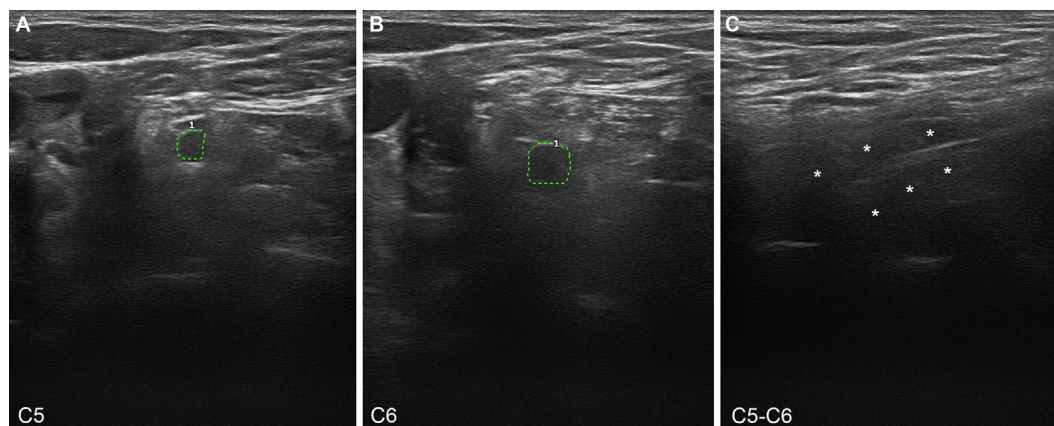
US of the ventral rami of the left fifth and sixth cervical nerves of case 12 with initial equivocal electrophysiological pattern evolving into AIDP (see Table 1 and Fig. 1); sonograms were obtained on day 6 after onset. (A and B) Short-axis sonograms showing enlarged CSAs of both cervical nerves (dotted green tracings; for values see Table 2); note that perineurial hyperechoic rims are not identified and that the edge between the nerve and the surrounding fat is not clear. (C) Sagittal sonograms showing blurred boundaries of both nerves (asterisks). (For interpretation of the references to colour in this figure legend, the reader is referred to the web version of this article.)
